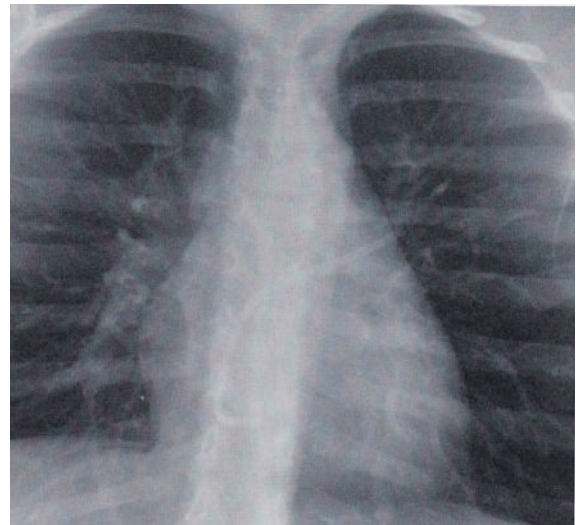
Chest X-ray 3 years after implantation of the Port-a-Cath prior to planned surgical removal of the system: the canula is disconnected from the box and straddles the PFO with the proximal end in the right atrium and the distal end in the upper left pulmonary vein, the catheter tip is seen just protruding outside the radiological heart shadow.
